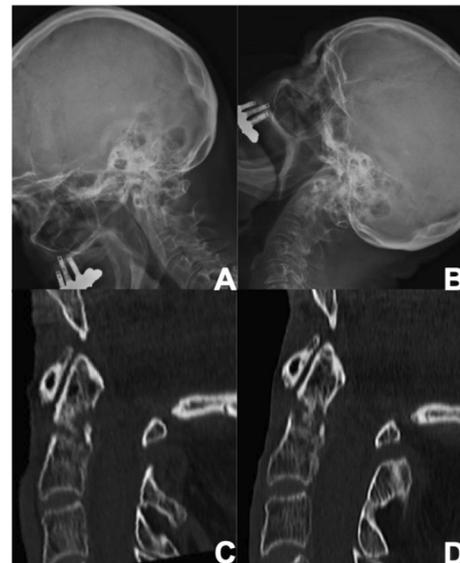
Dynamic cervical spine x-rays (flexion, A; extension, B) at 3 months and dynamic cervical spine CT-scan (flexion, C; extension, D) settling any doubts on evolutionary instability 6 months after injury.
